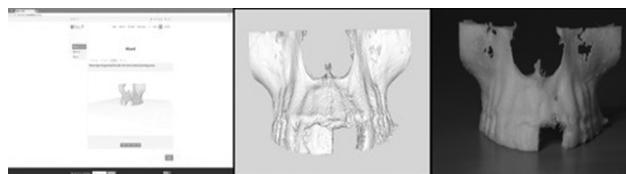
Obtaining a 3D model from the STL file. First the CBCT data of each patient is acquired, then the Dicom files are transformed to STL files through the website www.oral3d.eu obtaining the virtual 3D model (STL files processed). At the end of the process the 3D model is printed. STL, standard tessellation language.
